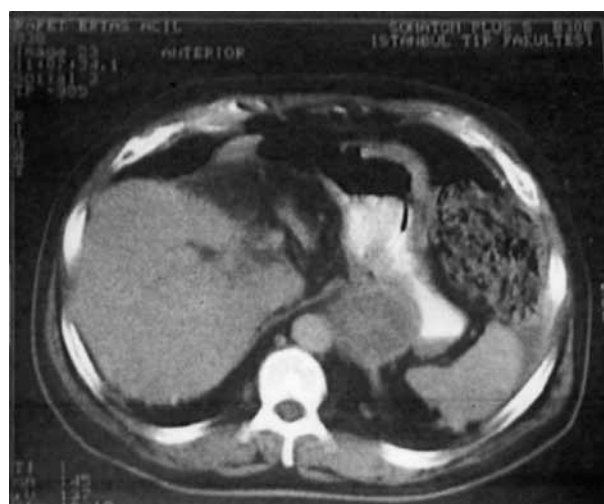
CT demonstrates aortic aneurysm with the delineation of the gastro-aortic border and a towel placed during the first operation lying above the spleen.
